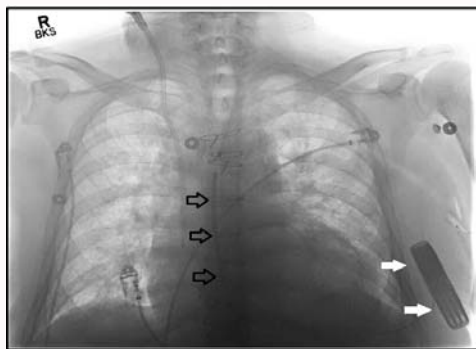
Chest radiograph demonstrating displacement of the S-ICD electrode along the right parasternal border. Black arrows = Electrode; White arrows = Pulse generator.
